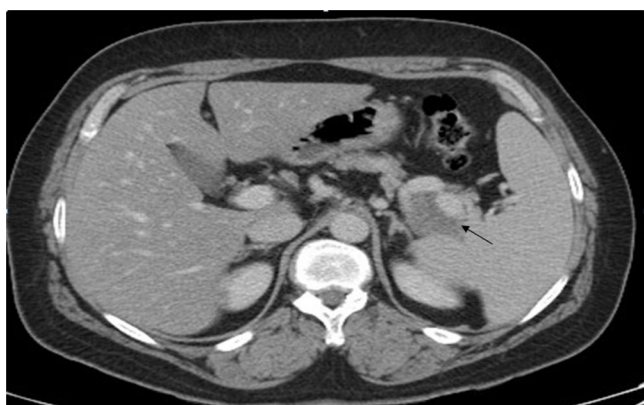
CT image of solid-cystic mass in the tail of the pancreas (black arrow).
